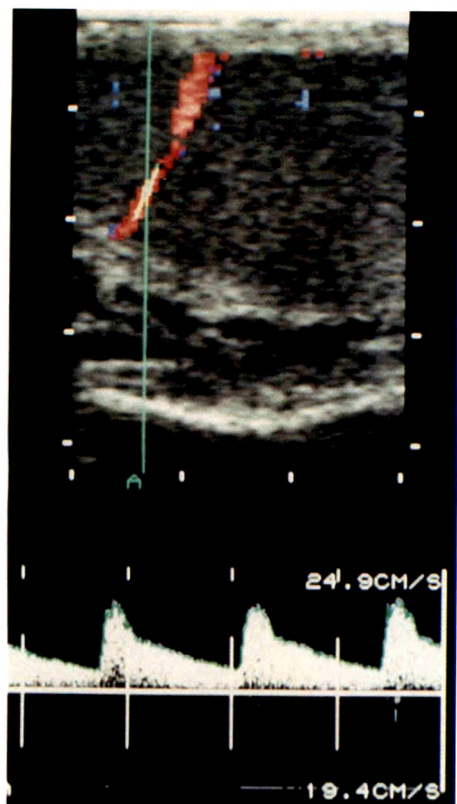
Color Doppler ultrasound image and velocity waveform from intratesticular artery. Vessel is identified on real-time image, and range-gated cursor is placed over region of interest. Doppler frequency shift obtained from vessel is converted to velocity by correcting for angle of blood flow, as with conventional duplex Doppler.
